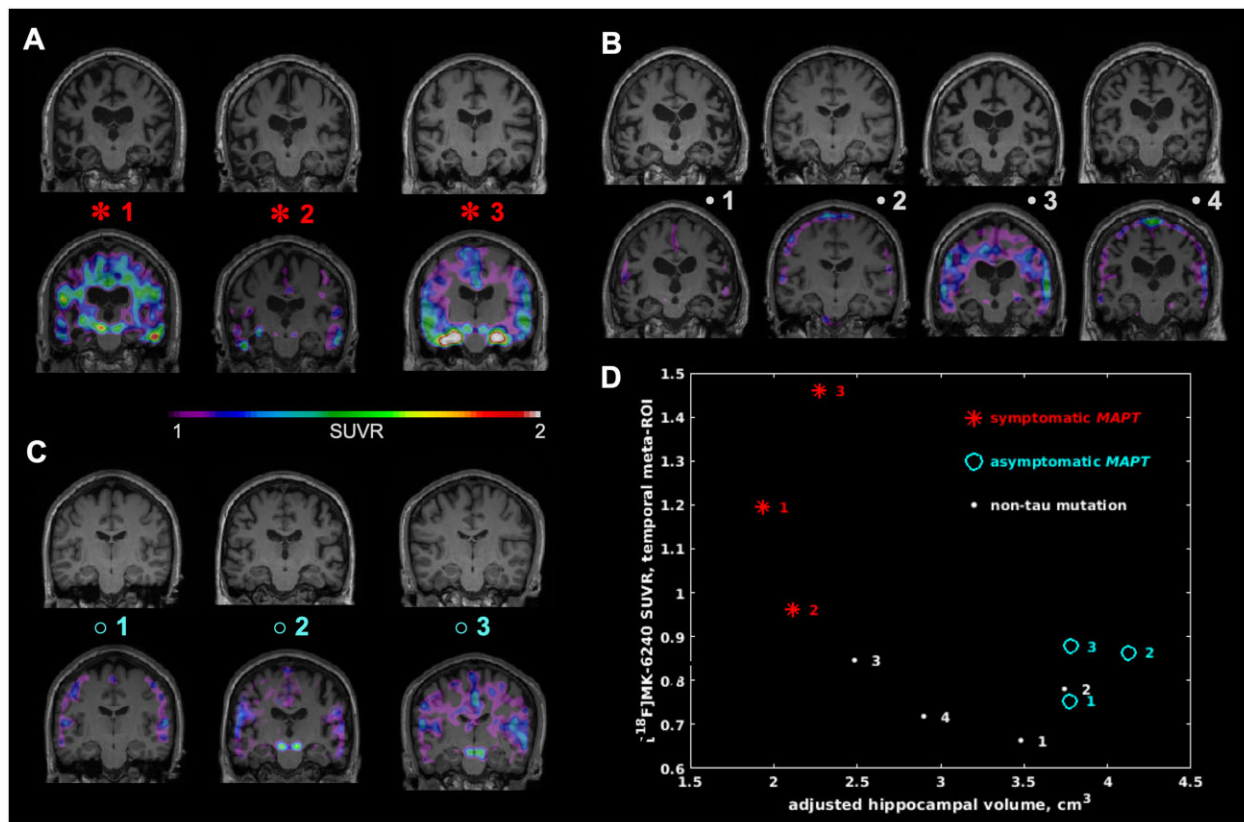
Hippocampal Atrophy versus ¹⁸F-MK-6240 temporal meta-ROI SUVR. Hippocampal atrophy and its association with MK-6240 SUVR in the temporal meta-ROI for the studied FTD cases. The T₁-weighted MRI maps are shown both alone (top) and with MK-6240 SUVR overlaid (bottom) for (A) symptomatic MAPT, (B) non-tau mutation FTD and (C) asymptomatic MAPT cases. (D) Adjusted hippocampal volume plotted versus MK-6240 SUVR in the temporal meta-ROI for each FTD case in this study. Note the three symptomatic MAPT cases having the lowest hippocampal volume and the highest MK-6240 SUVR among all cases.
